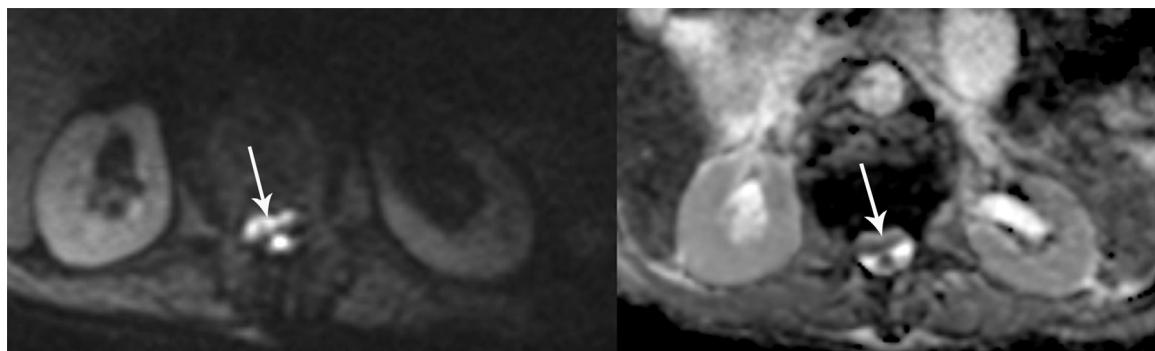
DWI showed the epidural empyema to be brightly hyperintense (Left), and the ADC map demonstrated that the diffusion abnormality was caused by restricted diffusion as expected (Right).
